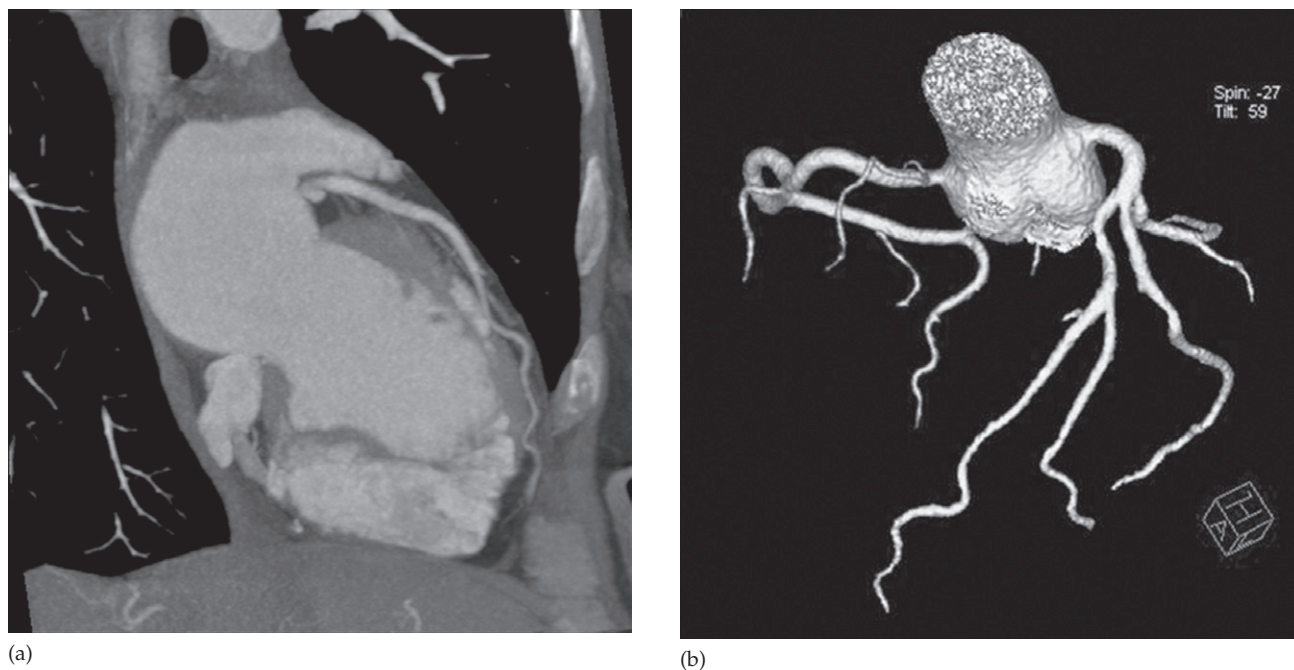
CT coronary angiography showing haemodynamically insignificant coronary artery disease. (a) Oblique coronal reconstruction showing the left coronary artery on the posterior surface of the heart. (b) Three-dimensional reconstruction of the aortic root and both coronary arteries.
